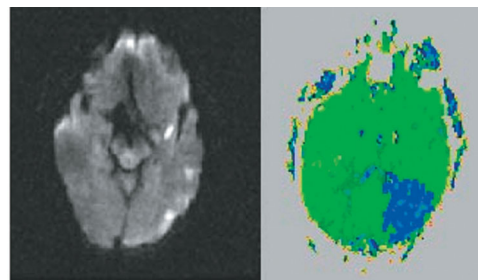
Case 3's DWI (left) and PWI (right) scans performed within 1 h of the naming tests (without intervention), when written naming of nouns was impaired.
